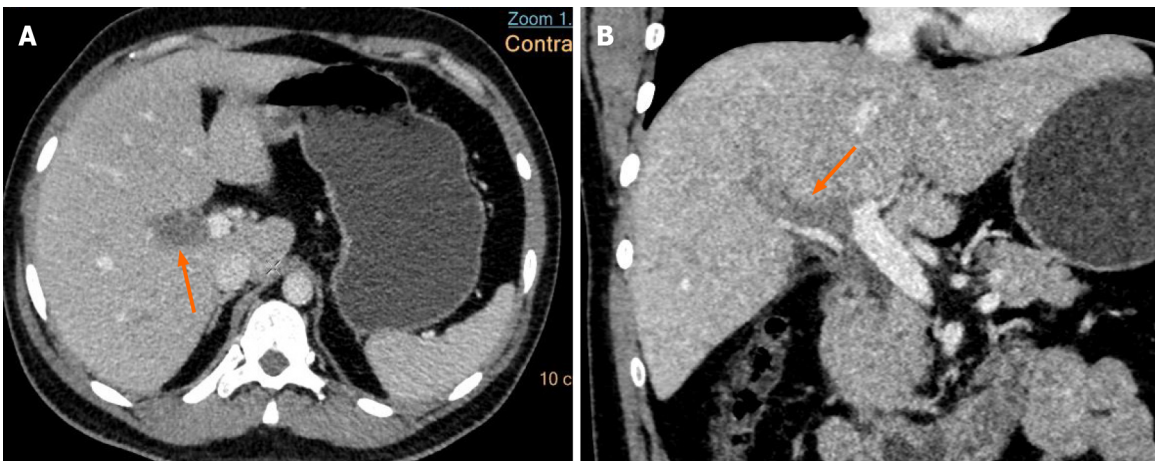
Venous thrombosis diagnosed in a coronavirus disease 2019 patient presenting with abdominal pain. A: Axial; B: Coronal. Contrast enhanced computed tomography (CT) images of the abdomen show a hypodense filling defect in the main portal vein at the hilum extending into the right branch (orange arrows in A and B), suggestive of portal vein thrombosis. There were no features of mesenteric ischemia seen on the CT.
